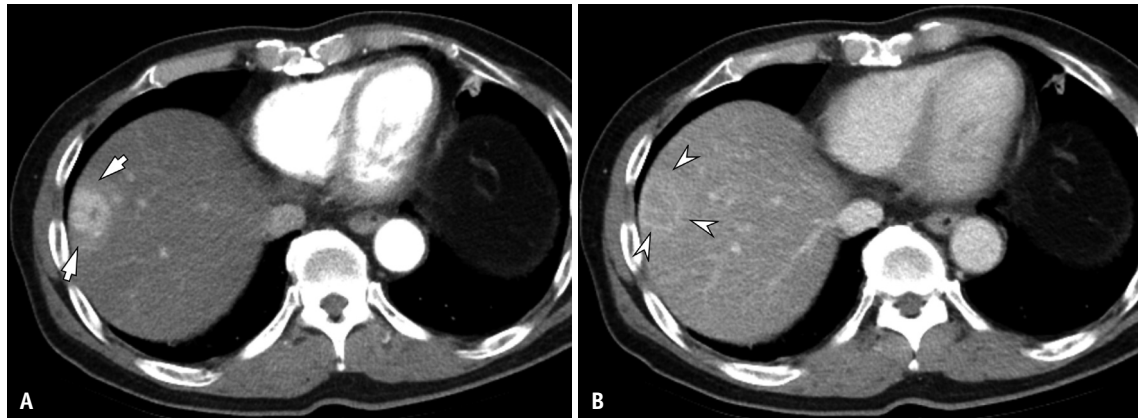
A 70-year-old man with surgically confirmed HCC. A: A 26.7-mm mass shows non-rim arterial-phase hyperenhancement in the arterial phase (arrows) on CT. No portal washout is observed (not shown). B: In the delayed phase, an enhancing capsule (arrowheads) is present, while delayed washout is not observed in comparison with the adjacent liver parenchyma. In v2018, the mass is classified as “indeterminate nodule,” while it is “probable HCC” in v2022. HCC = hepatocellular carcinoma
